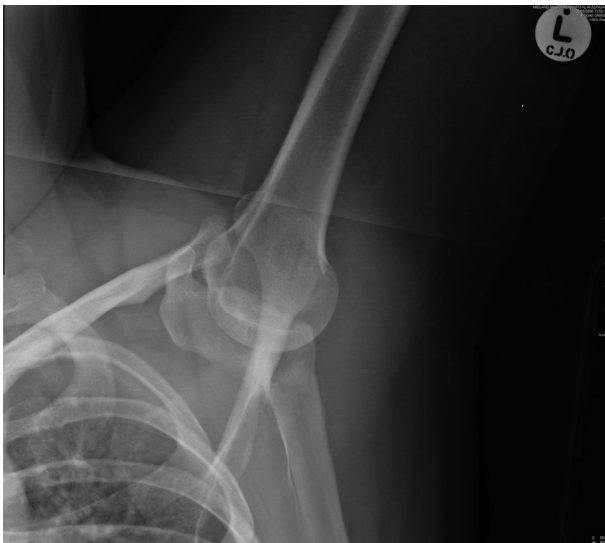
Left shoulder X-ray revealing inferior dislocation. The humeral head is positioned below the glenoid fossa and the shaft of the humerus is parallel to the spine of the scapula.
